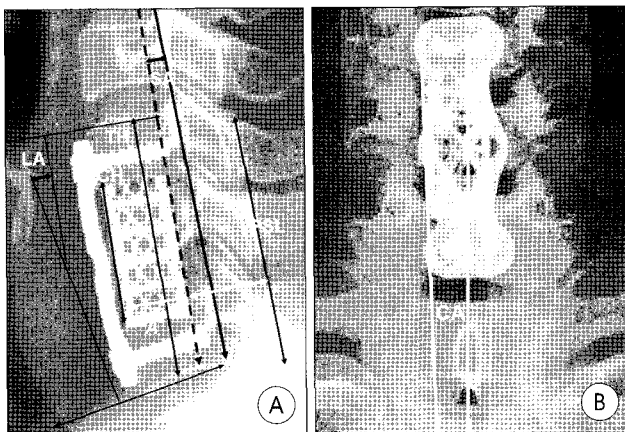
A : Lateral radiograph obtained on a patient undergoing titanium mesh cage (TMC)-augmented stabilization after corpectomy. The settling ratio was determined by the ratio of the cage height (CH) and the distance between the superior end of the superior vertebra and the inferior end of the inferior vertebra (TH). Sagittal displacement was determined by dividing the distance between the posterior margins of the cage to the posterior spinal line (B) by the width of the cage (A). The sagittal angle (SA) was subtended by the posterior edge of the cage and the posterior spinal line. Local kyphosis (LA) was derived by the Cobb method of measurement. B : The coronal angle (CA) was subtended by the lateral margin of the TMC and the spinous process.
